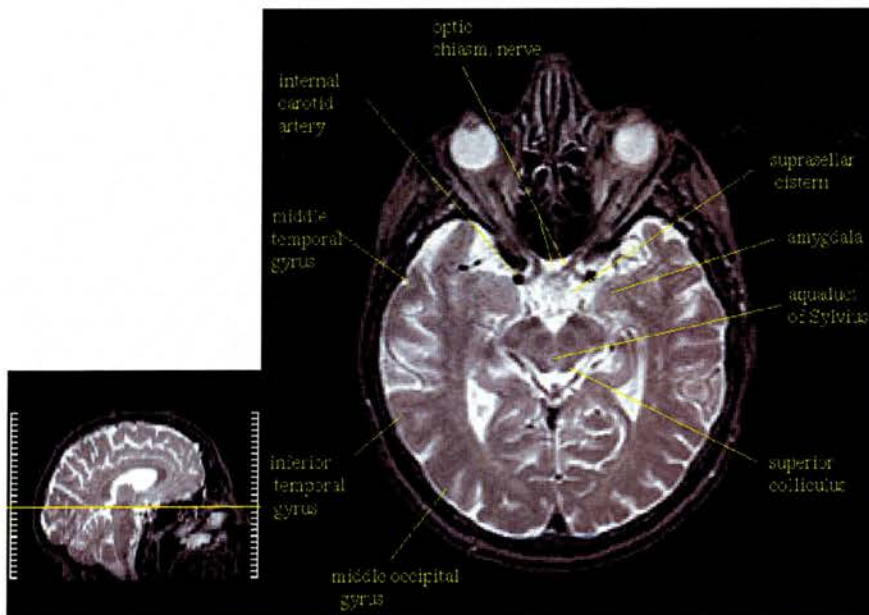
MRI scans showing the position of the human amygdala (T2 weighted slice 23)
